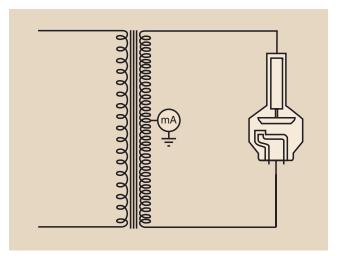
The mA meter is in the x-ray tube circuit at a center tap on the output of the high-voltage step-up transformer. This ensures electrical safety.
